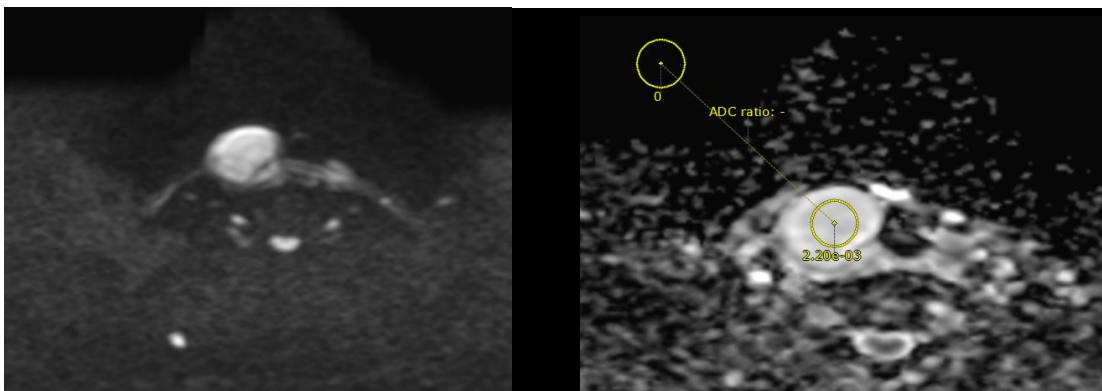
Benign right thyroid nodule, A axial DWI, B: axial ADC map DWI showing right thyroid nodule of rounded to oval shape with high DWI signal, at ADC map, the ADC value was measures about 2.2×10^{-3} .
